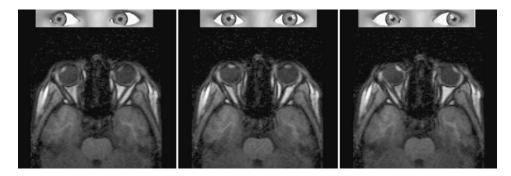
Typical frame of an orbital cine MRI sequence. The corresponding position of the eyes is shown. (With permission from M. D. Abrámoff, "Objective Measurement of Motion in the Orbit" [Ph.D. thesis] Transatlantic Publishing, New York, 2001.)
